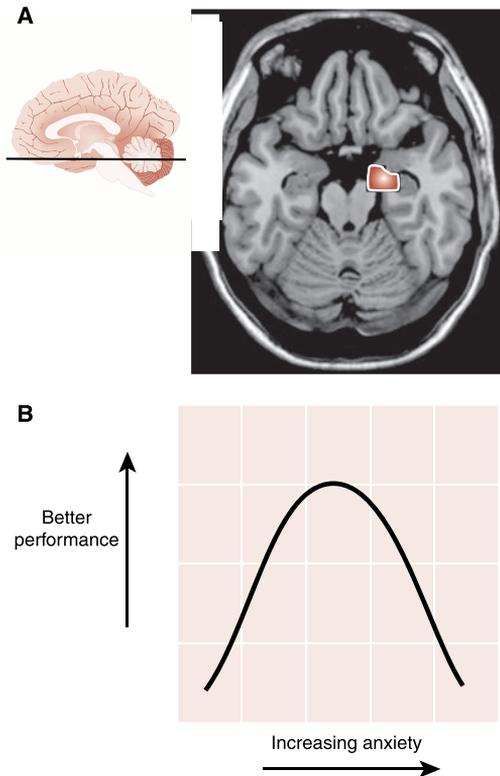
● A. Increased activity at the level of the amygdala when patients with anxiety anticipate making a public speech. B. Hypothetical upside down U curve showing benefits and problems of anticipatory anxiety. (Functional magnetic resonance imaging from Lorberbaum JP, Kose S, Johnson MR, et al. Neural correlates of speech anticipatory anxiety in generalized social phobia. *Neuroreport*. 2004;15(18):2701-2705.)
